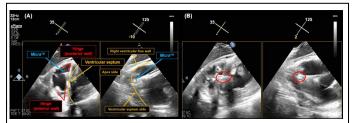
(A) Transesophageal echocardiography images of leadless pacemaker implantation in the transgastric right ventricular inflow view. (B) Transesophageal echocardiography images of the leadless pacemaker after release in the transgastric right ventricular inflow view. The distance between the Micra and the posterior wall hinge was 17.0 mm. The threshold was 1.0 V at 0.24 ms, R wave 3.6 mV, and impedance 510 Ω .
